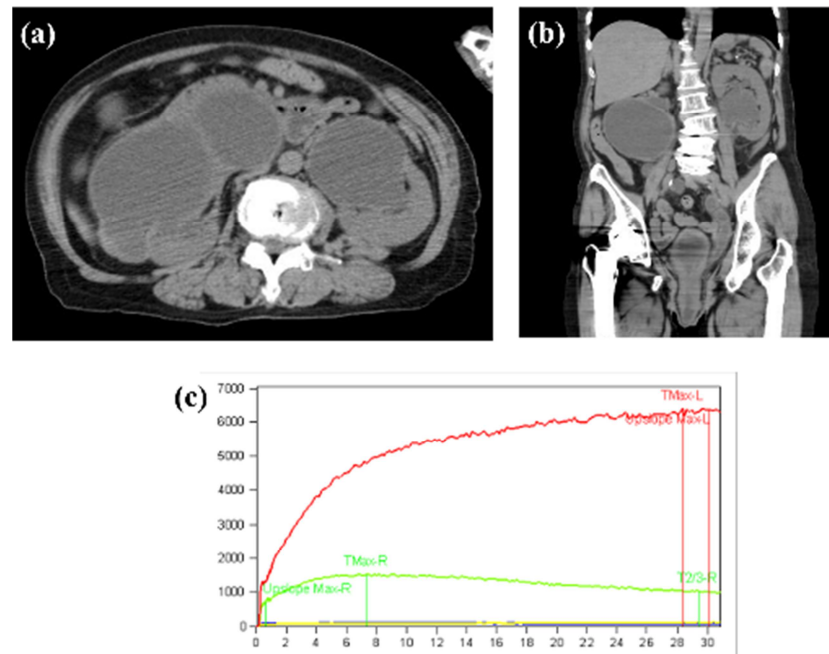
CT at her initial visit and renal scan after right nephrostomy.
